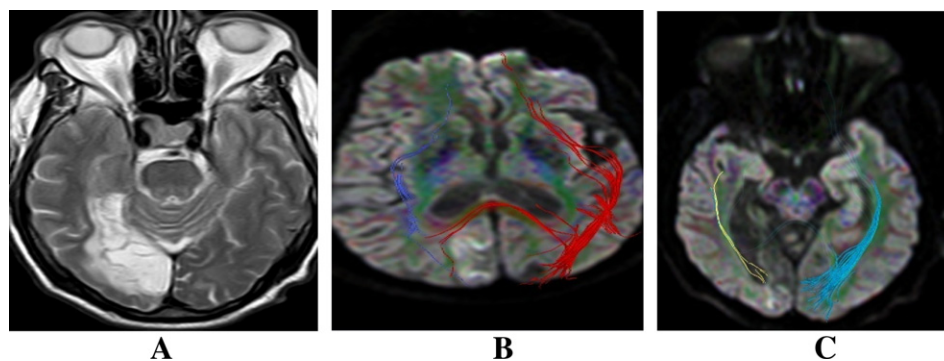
Patient # 12 admitted with left sided weakness. (A) The axial T2 weighted image showed a wide hyperintense area of ischemic infarction is seen involving the right parieto-occipital region. (B and C) The diffusion directional colored image and the tractography colored image superimposed on the DWI showed thinning out of the inferior parieto-occipital fasciculus fibers on the affected right side in comparison to the left side. This patient had poor outcome with left sided hemiparesis on discharge.
